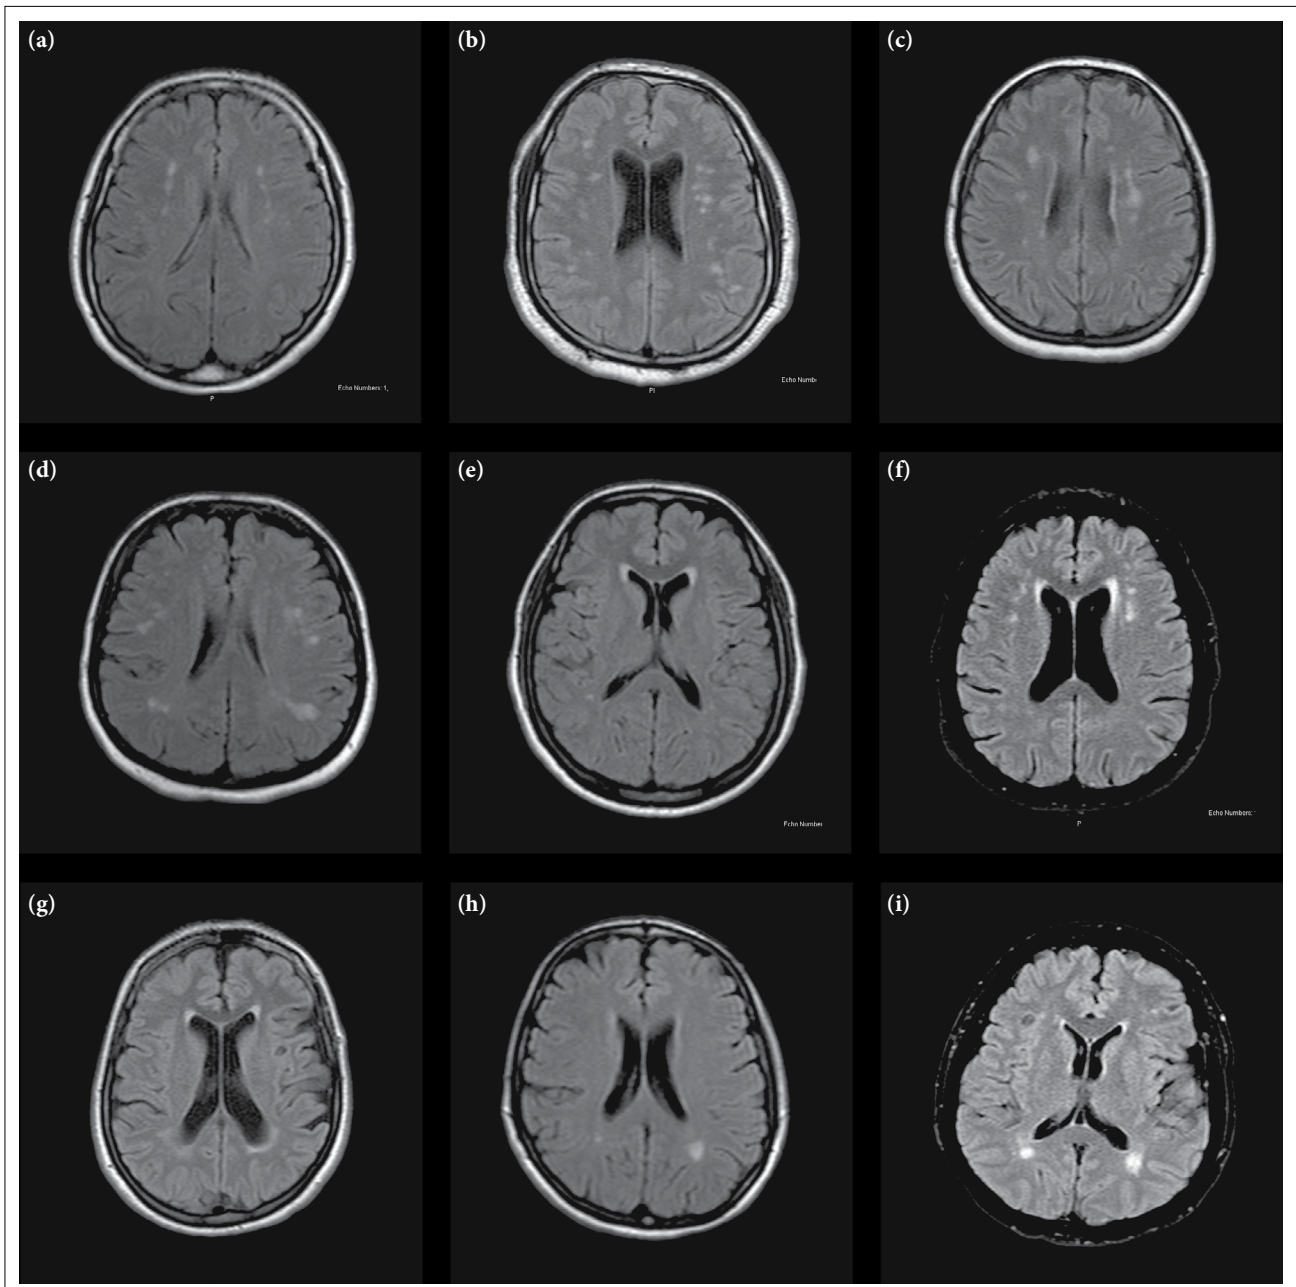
Brain MRI Lesions: Predominantly subcortical with a tendency for bilateral localization and symmetry (a–d). Periventricular capping; increased signal intensity around the poles of the lateral ventricles (e–g). Lesions not in contact with the ventricles (h–i).
